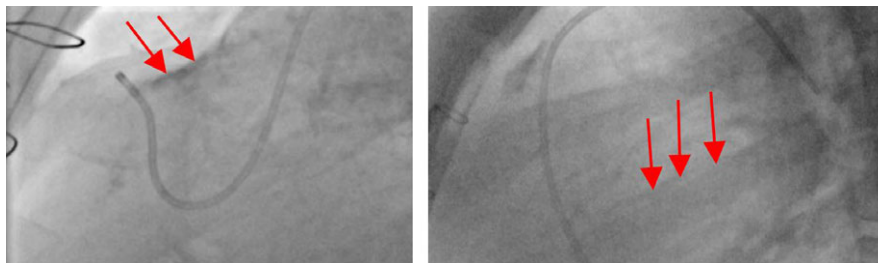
Image artifacts (indicated by red arrows) in X-ray images. [Color figure can be viewed at wileyonlinelibrary.com]
